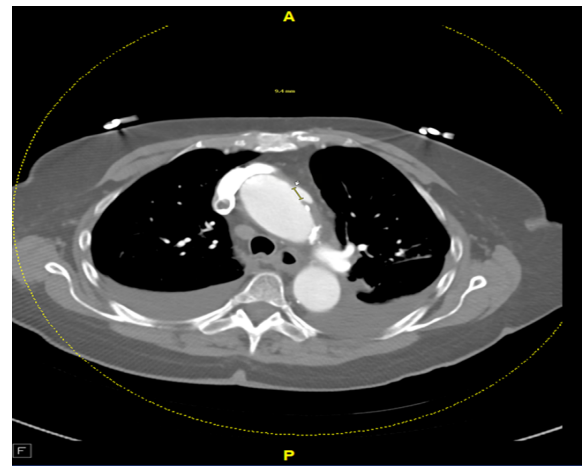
CT-PE with contrast showing ascending aortic aneurysm with aortic root irregularities concerning for aortic dissection versus pseudo aneurysm formation.
